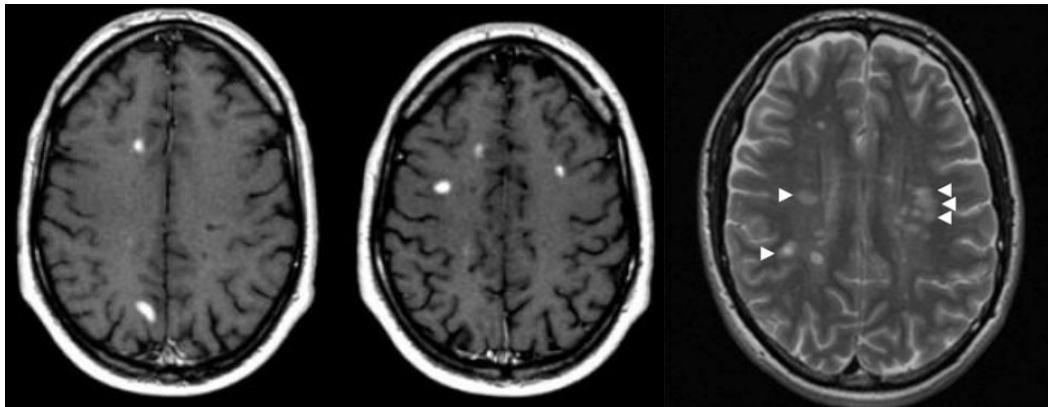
Detection of lesion in MRI images (axial view)
